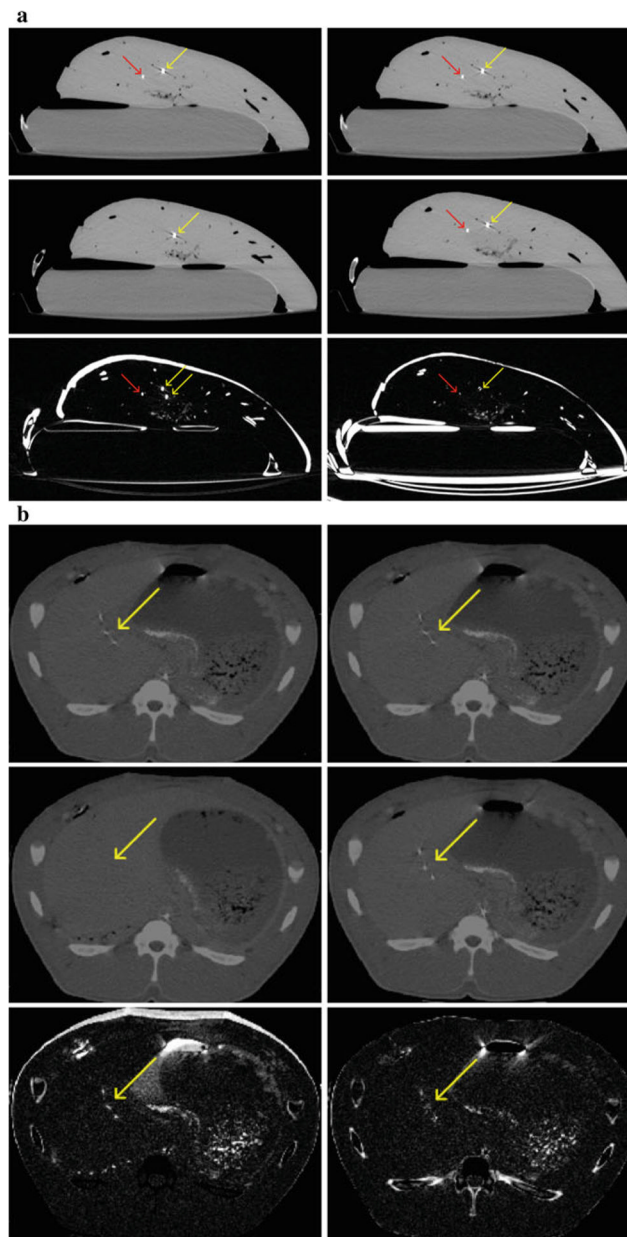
Ex vivo results. a *Top row:* identical sections of predeformation CT. *Middle row:* same section of postdeformation CT without (*left*) and with (*right*) registration per needle tracking. *Bottom row:* difference image between the two CT sections in each column. Misregistration near the needle is reduced after recovering the deformation, which means improved spatial alignment. *Red arrows:* needle positions. *Yellow arrows:* target positions. In vivo results. b *Top row:* identical sections of predeformation CT. *Middle row:* same section of postdeformation CT without (*left*) and with (*right*) registration per needle tracking. *Bottom row:* difference image between the two CT sections in each column. Misregistration is reduced after recovering the deformation, which means improved spatial alignment. *Yellow arrows:* target positions
